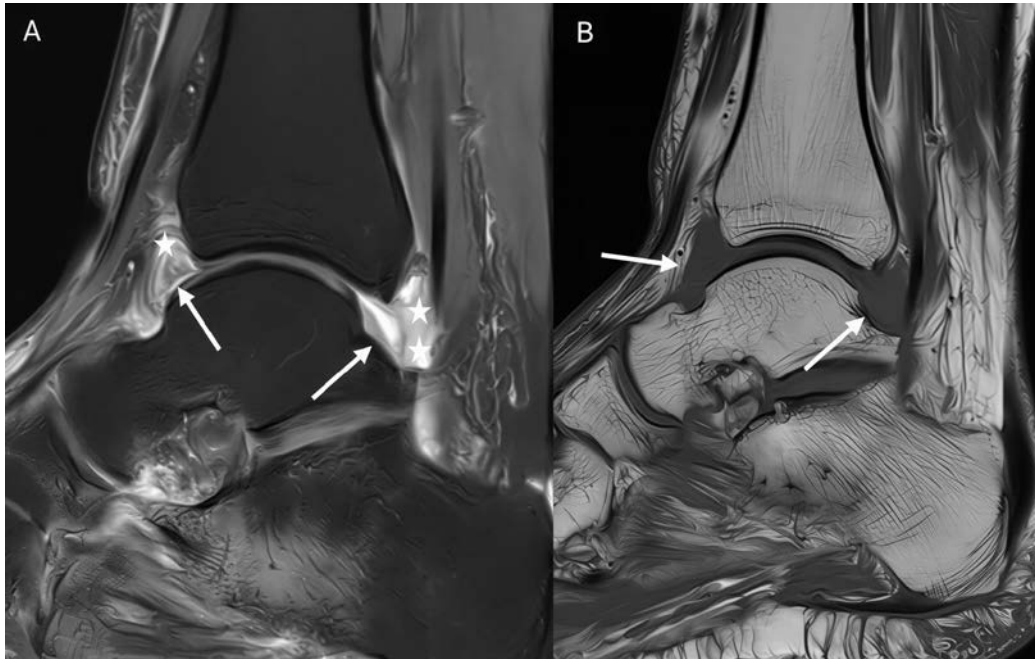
Sagittal PD-weighted fat-saturated image (A) demonstrates joint effusion (arrows) and synovial thickening (stars) with high signal. The corresponding T1-weighted image (B) shows low to intermediate signal synovial proliferation (arrows). In contrast to TSGCT, the synovial proliferation lacks diffuse low signal intensity and susceptibility-related blooming, while the prominent fluid signal and surrounding edema favour inflammatory arthritis.
